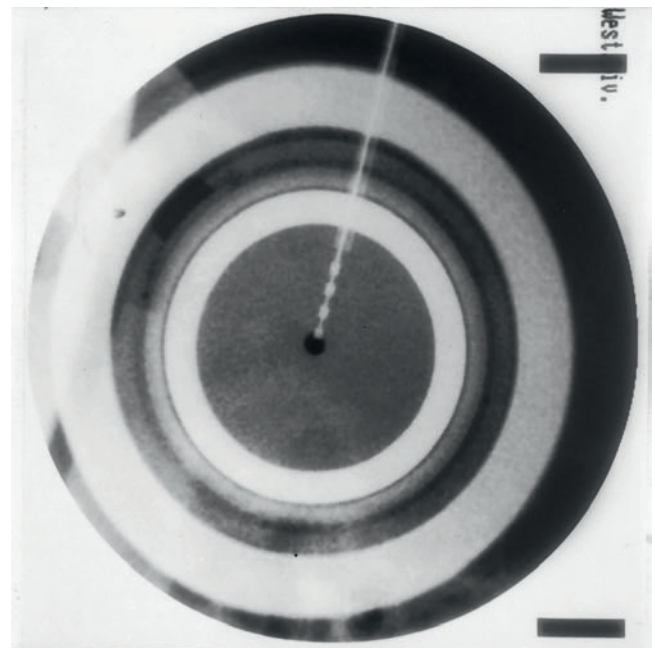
Intraoperative target verification. Intraoperative stereotactic radiograph of the DBS (deep brain stimulation) electrode at the target. The electrode is introduced through a precoronal bur hole and directed posteriorly and ventrally. The position of the electrode is monitored via fluoroscopy. The crosshairs indicate the target, which is also the center of the stereotactic ring. Note the appearance of the four poles.
